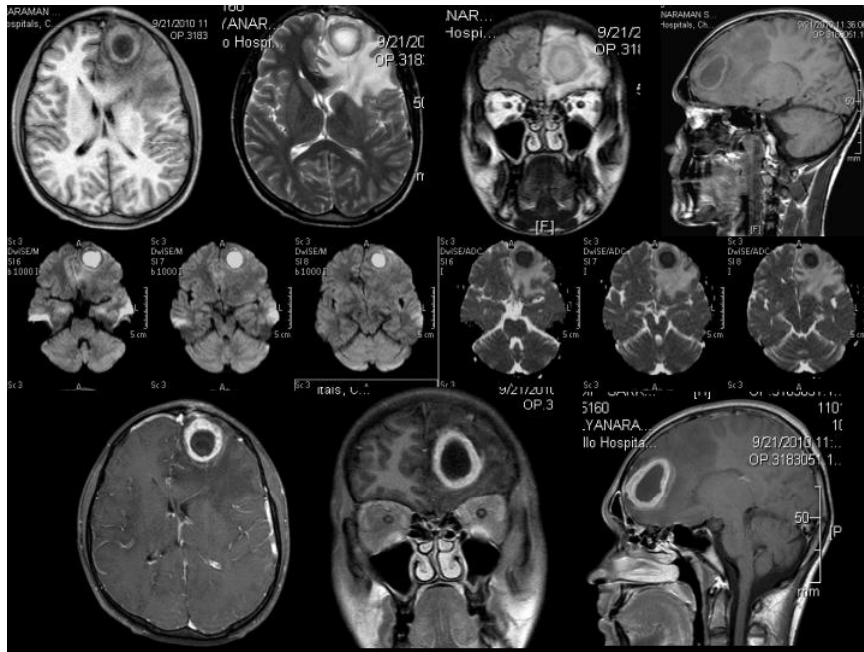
MRI shows a circumscribed cystic lesion with thick peripheral enhancing wall in the left frontal lobe; lesion displays central hyperintense area and hypointense rim on T2 WI and restricted area on DWI suggestive of abscess
